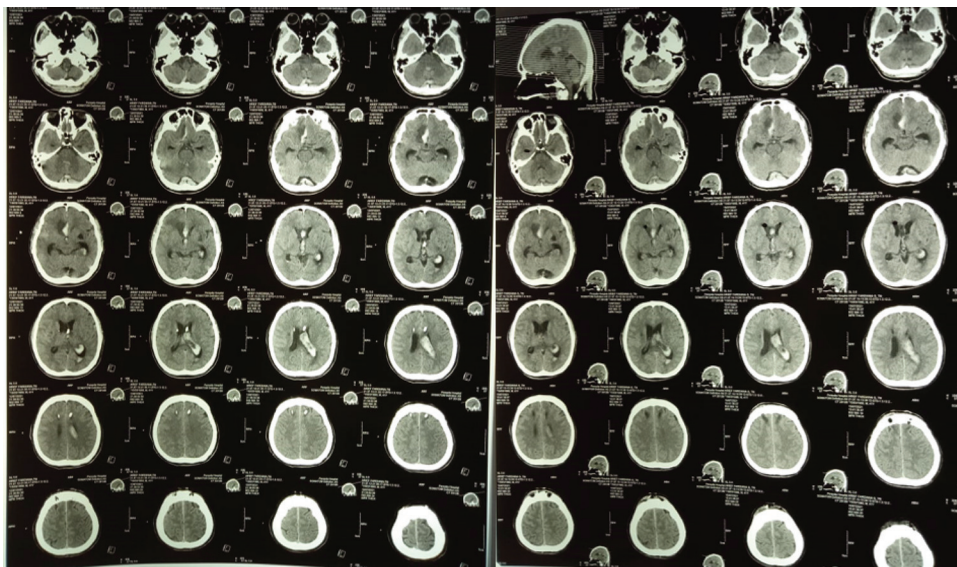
(a, left) development of the CT scan image of IVH patient on day five evaluation, (b, right) CT scan image on day seven evaluation postoperative EVD.
